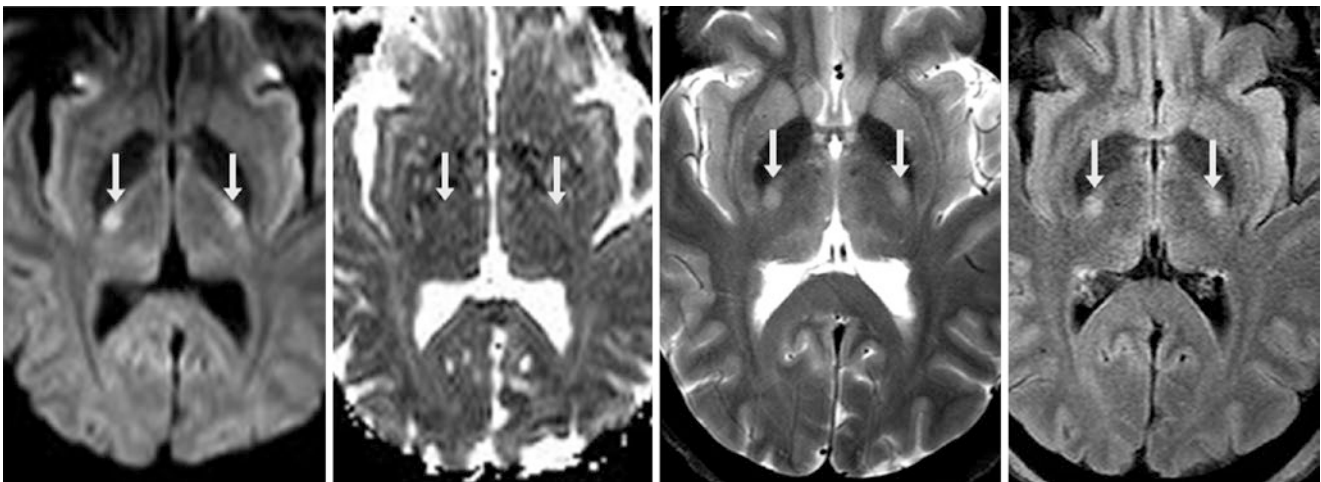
A 49-year-old with a 3 T MRI that demonstrates hyperintensity within the PLICs bilaterally (*arrows*) on the regular “trace” DWI map (*left*) but without corresponding bright signal (*i.e.*, edema) on the ADC map (*left middle*). There is also normal, bright signal within
